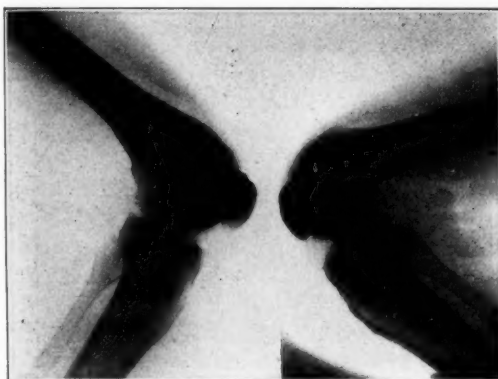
Path. No. 27057. Latent unhealed bone cyst. Male, age 33. X-ray ten days after injury.
